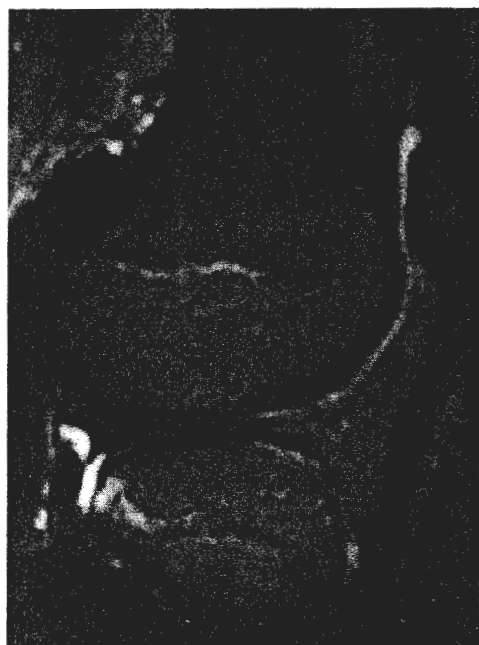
This patient sustained an anterior knee dislocation. She was found to have anterior cruciate tears of both knees and it was suggested that she either stop cheerleading or have her knees reconstructed. She stopped cheerleading and while participating in a school play jumped from a 3 ft height. Radiographs of AP (A), lateral view (B) show anterior knee dislocation. C. The magnetic resonance imaging (MRI) scan shown on sagittal cut demonstrates an intact posterior cruciate ligament, absent anterior cruciate ligament.
